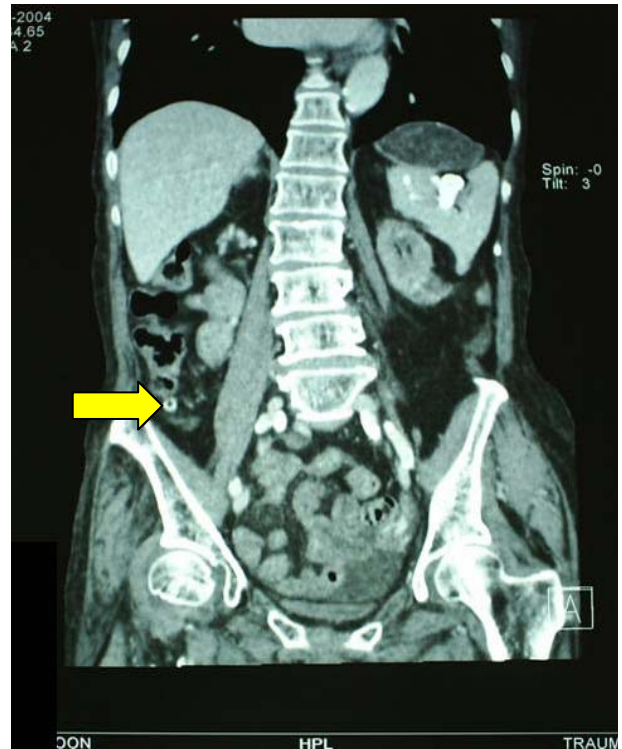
Reformatted coronal CT image of the bleeding from a caecal diverticulum (arrow).
